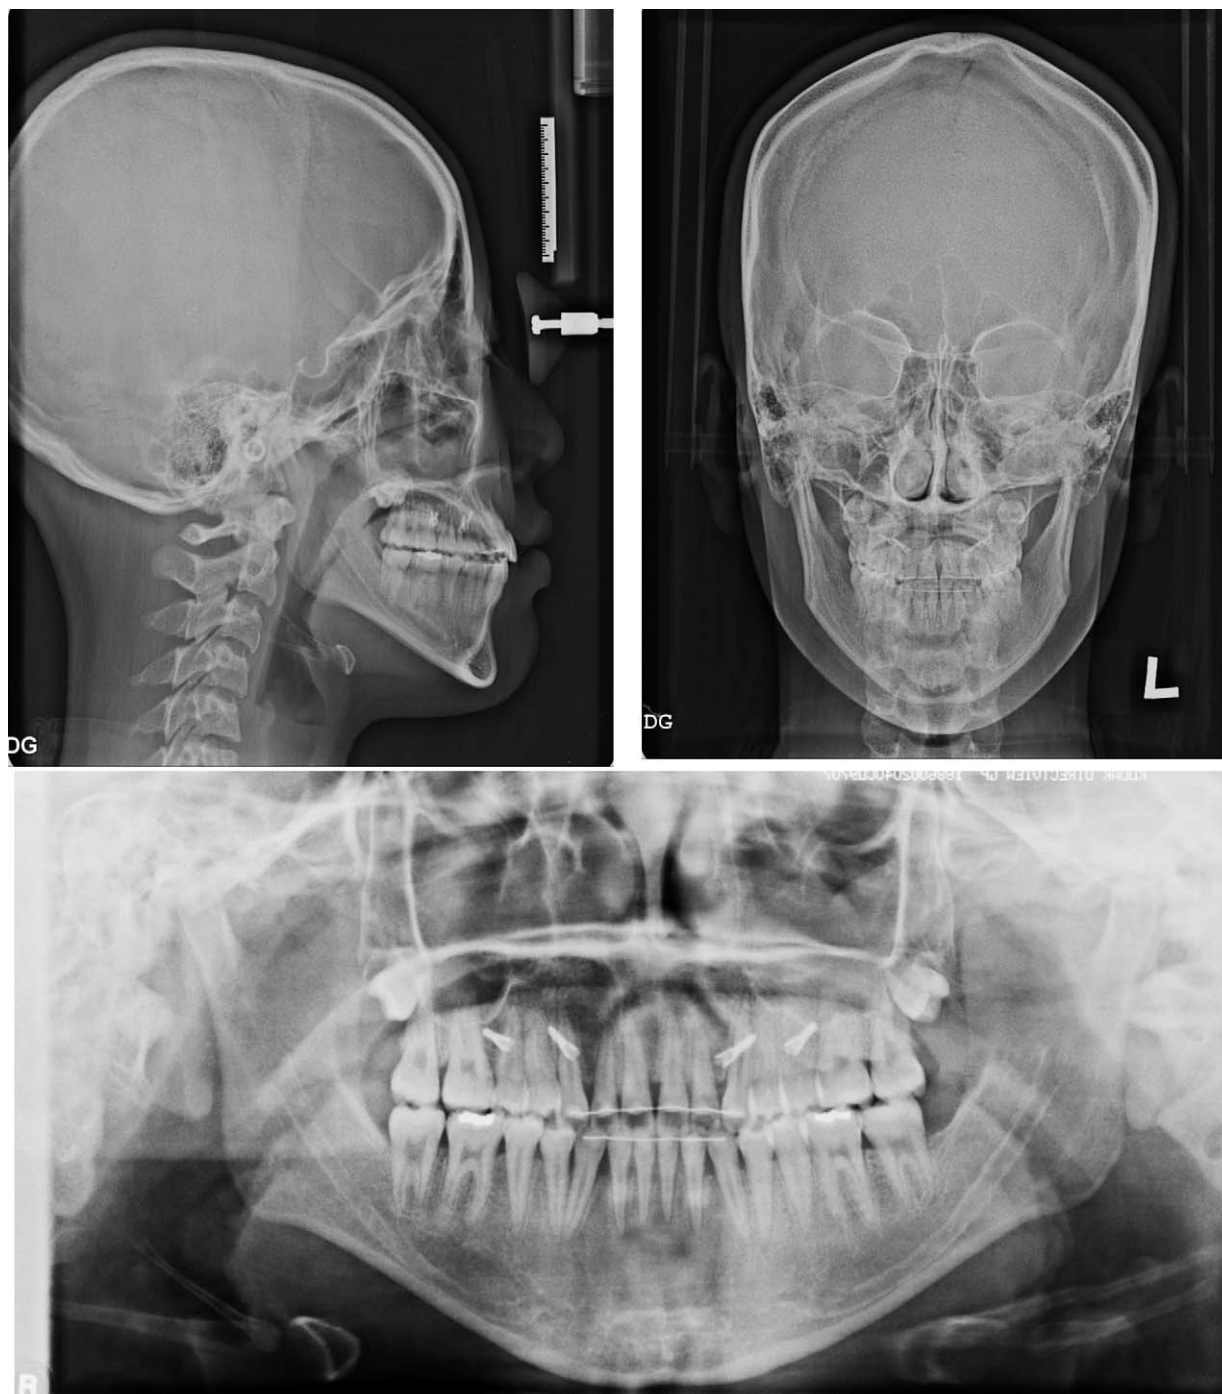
Posttreatment radiographs after maxillary expansion: lateral and posteroanterior cephalograms, panoramic radiograph.
